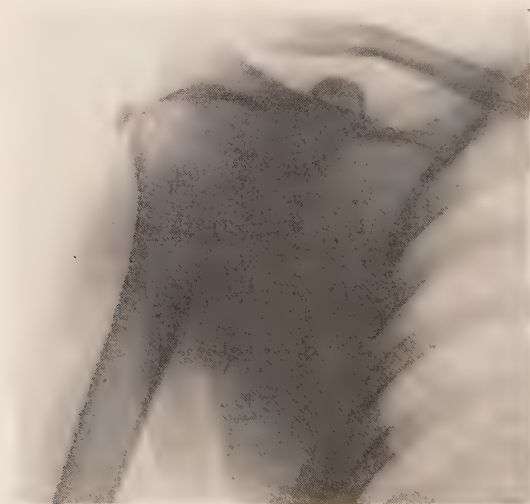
Subdeltoid bursitis with calcification. (Roentgenogram by Dr. G. C. Bird.)
